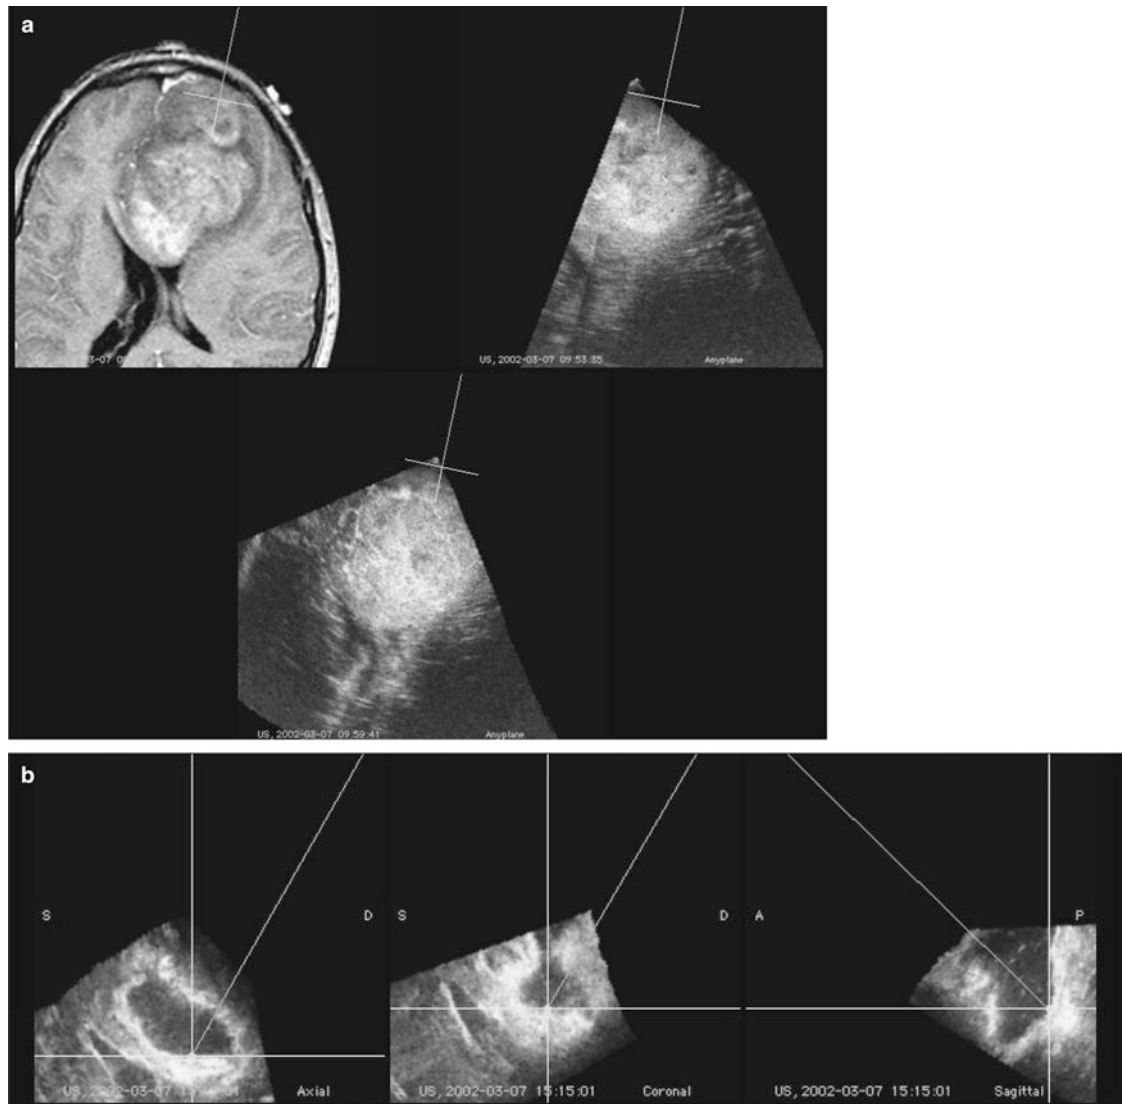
Intraoperative 3-D ultrasound before (a) and after resection (b) of a large frontal anaplastic oligodendroglioma
